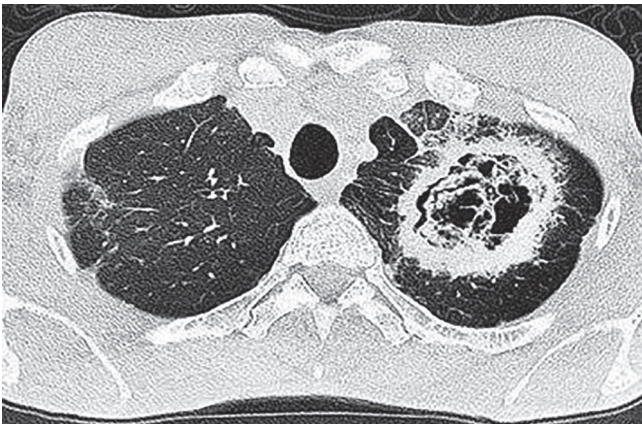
Thoracic CT indicating a cavitary lesion surrounded by adjacent consolidation in the left upper lobe.
